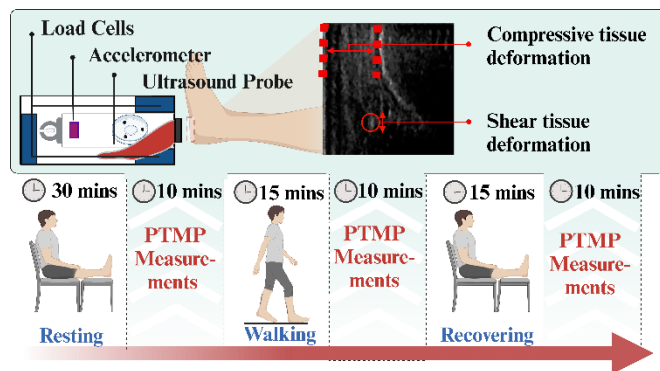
Ultrasound measurement device used to collect plantar tissue material properties during resting and walking.
